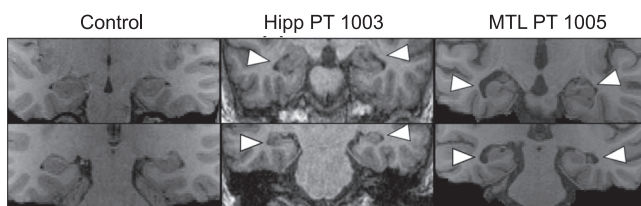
Patient lesion images. Sample MRI images for a control participant, a patient with selective hippocampal damage (1003) and one patient with damage extending into the medial temporal lobe (MTL) (1005). All images are of coronal slices in the head and body of the hippocampus
